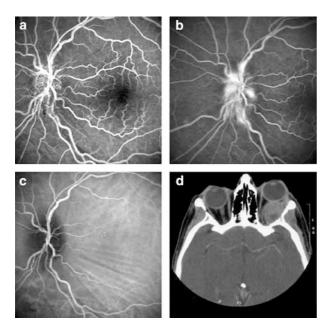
(a) Early fundus flourescein angiography (FFA) showing swollen optic disc and choroidal folds. (b) Late fundus flourescein angiography (FFA) showing optic disc swelling. (c) Indocyanine green angiography (ICG) showing swollen optic disc and choroidal folds. (d) Computerised tomography (CT) scan showing the orbital metastasis involving the left orbit.
